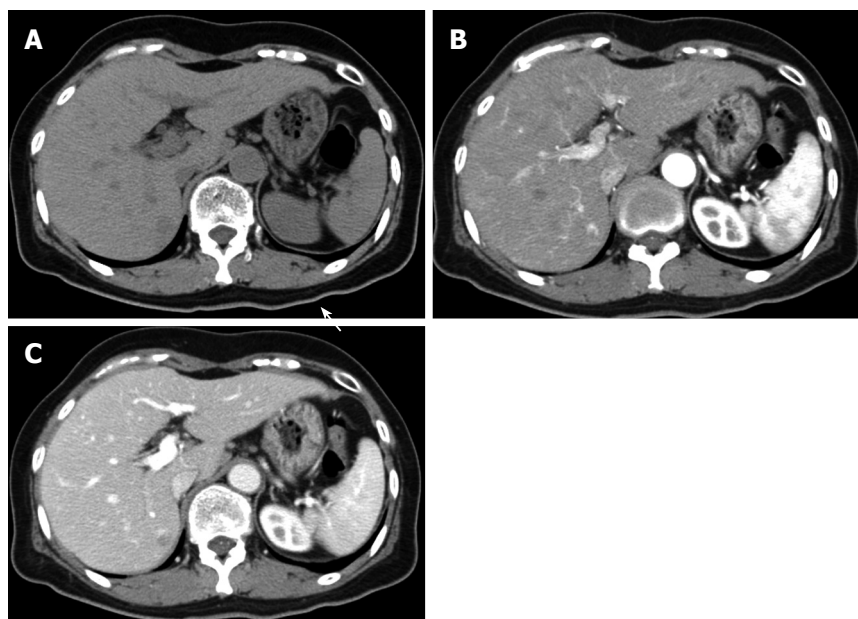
Computed tomography (CT) showing a 10 mm nodule in segment 7. A: A hypodense nodule in plane phase; B: A hyperdense nodule in the early phase after injection of contrast medium; C: A hypodense nodule in the late phase after injection of contrast medium.
